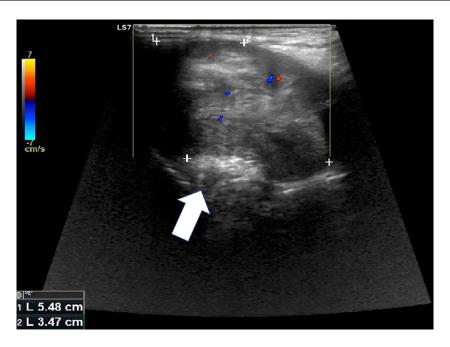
A hypoechoic mass with an ill-defined border was seen on color-Doppler mode ultrasonography in the right parotid gland (arrow).
